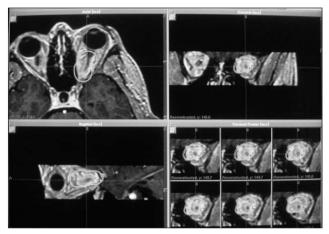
Snapshot image of the first patient (pONSM) taken during Gamma Knife treatment planning. Images showing axial, coronal, sagittal and coronal poster T1-weighted MRI views of a markedly gadolinium-enhanced homogenous tumor surrounding the left optic pathway, and isodose lines around the mass.
